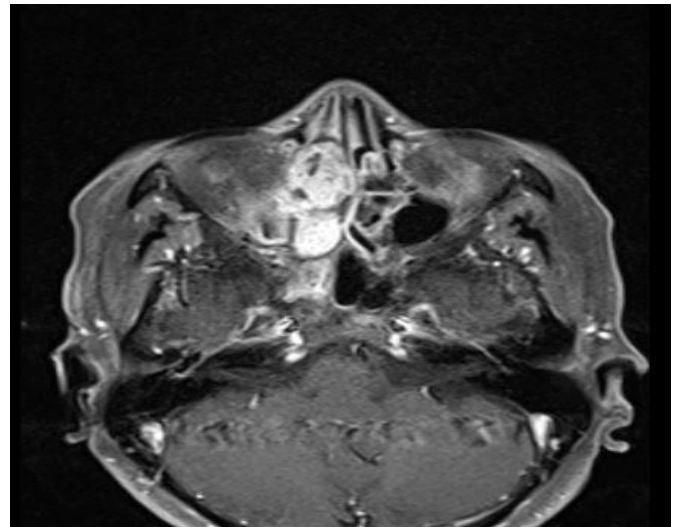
MRI Contrast T1 weighted image shows homogeneously enhancing soft tissue lesion in right nasal cavity and ethmoid sinus.
